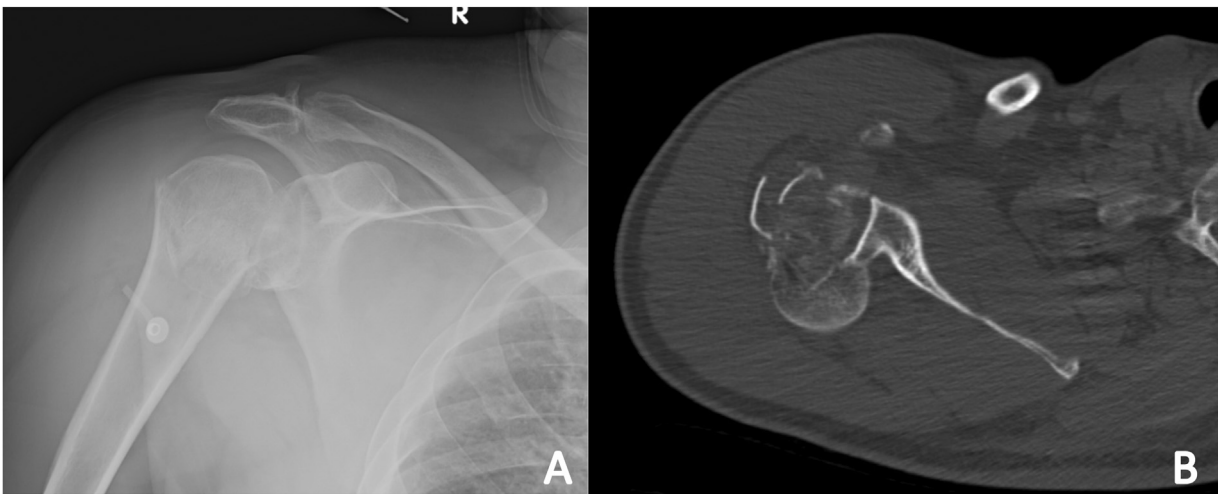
(A) AP radiograph of the right shoulder demonstrating a comminuted proximal humerus fracture. (B) Axial CT image of the right shoulder demonstrating a comminuted posterior fracture-dislocation of the proximal humerus.
